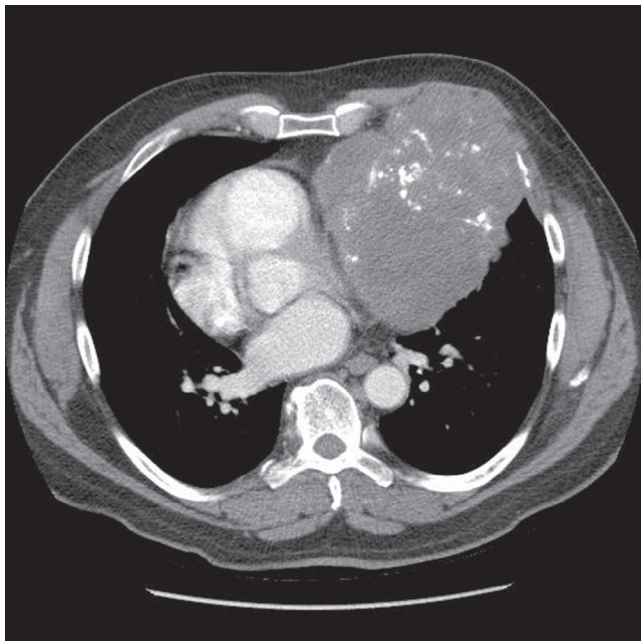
■ Computed tomography scan of an osteosarcoma of the left chest wall.
